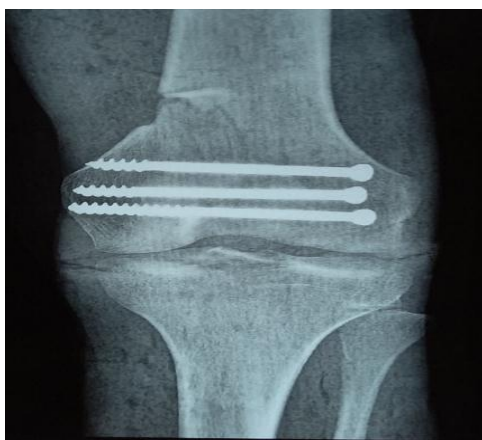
X-ray control at 4 months.
